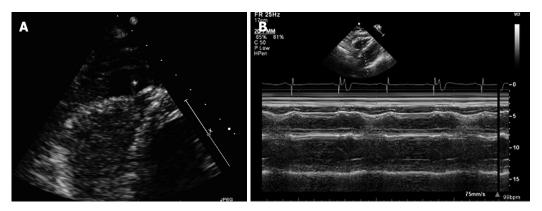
Transthoracic echocardiogram. A: Image is an apical 4 chamber view of a transthoracic echocardiogram showing a moderate sized localized pericardial effusion with an echo bright structure within the effusion suspicious for lead perforation; B: Image is taken in M-mode and demonstrates right ventricular diastolic collapse suggestive of increased pericardial pressures.
